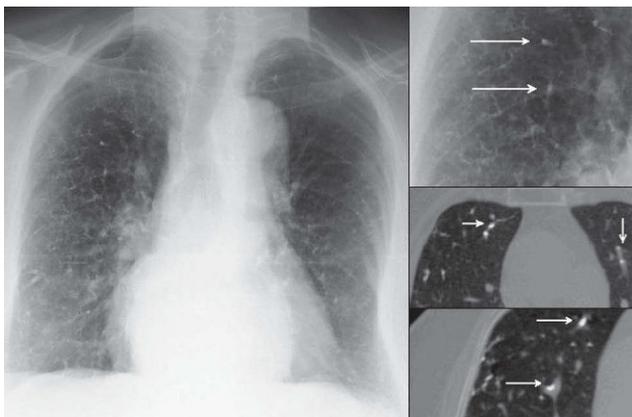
Multiple branching linear opacities in both pulmonary fields (top right, arrows). *Bottom right:* Close-up of the high resolution CT showing cement emboli (arrows) inside the pulmonary artery branches.
